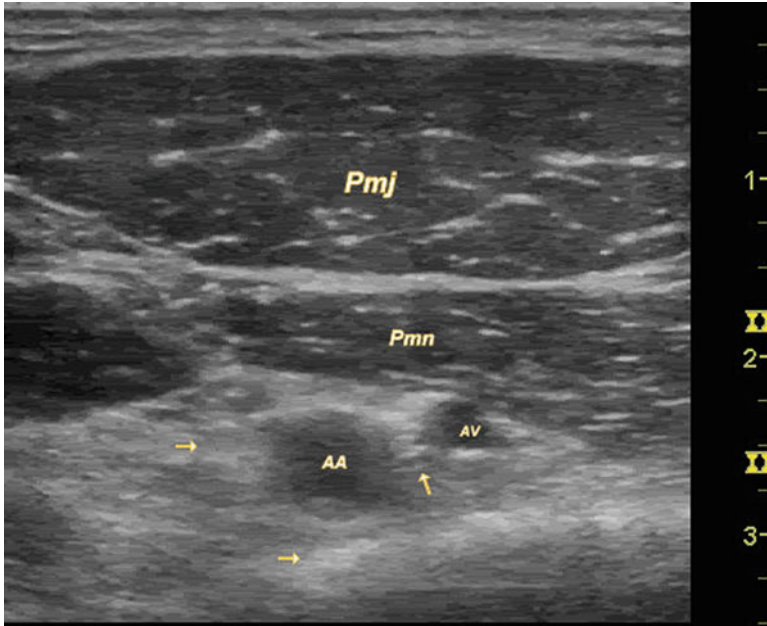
Ultrasound appearance of the infraclavicular nerve block. The pectoralis major (*pmj*) and pectoralis minor (*pnn*) cover the brachial plexus noted by *arrows*, which surrounds the axillary artery (*AA*). The small axillary vein (*AV*) is located caudal to the artery
